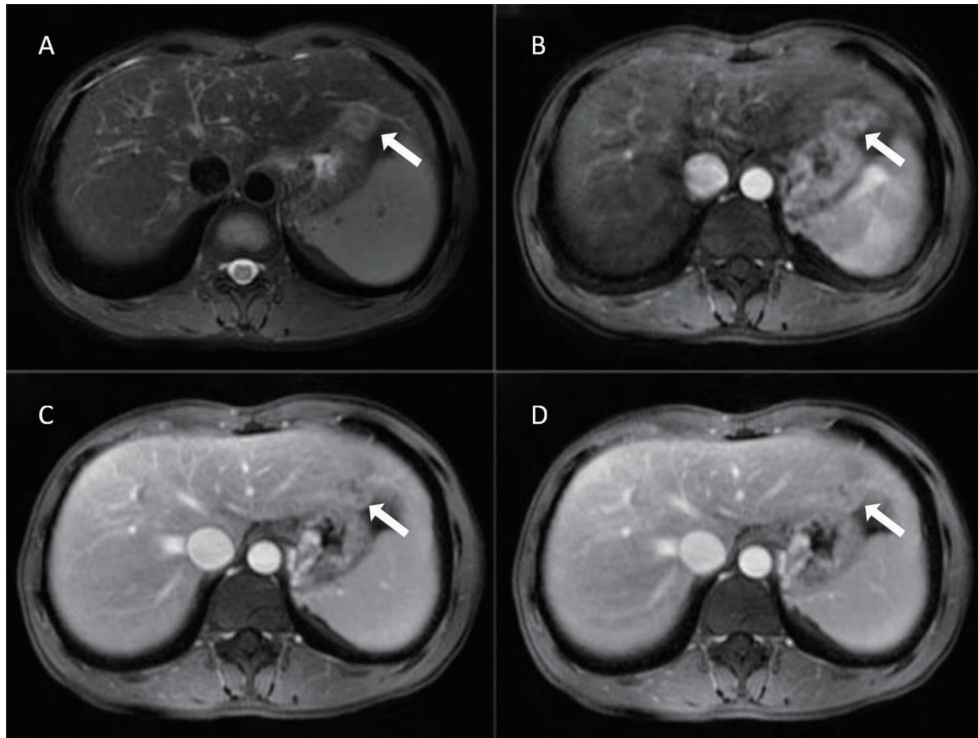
A cHCC-CCA lesion as shown on MRI. (A) An irregular hyperintensity tumor on T2-weighted imaging. During contrast study, the lesion shows heterogenous enhancement in the arterial phase (B), and mixed washout and persistent enhancement in the portal phase (C) and delayed phase (D). cHCC-CCA, combined hepatocellular cholangiocarcinoma; MRI, magnetic resonance imaging.
